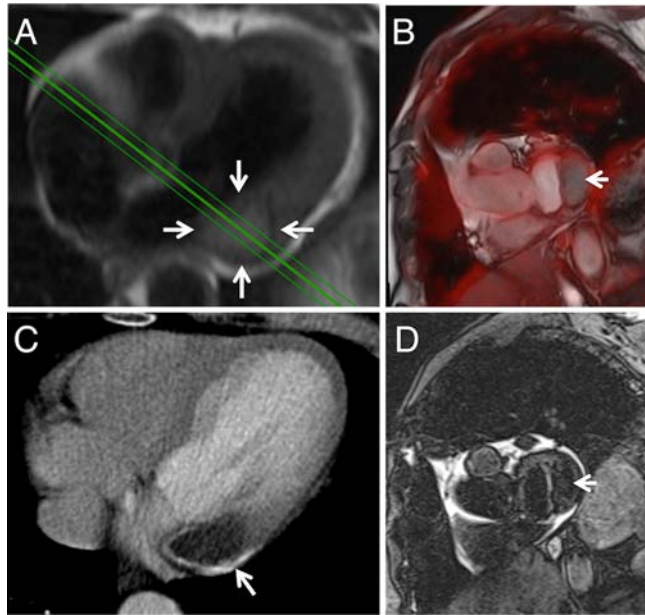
Axial HASTE image (A; arrows) of a lesion in the basolateral myocardial wall adjacent to the mitral valve. The lesion did not show any significant FDG uptake (fusion B; arrow). The lesion also showed calcifications on a CT scan (C; arrow) and was diagnosed as caseous calcification of the mitral annulus (Table 1, Patient 17). The lesion was hypointense on T2-weighted images (D; arrow).
